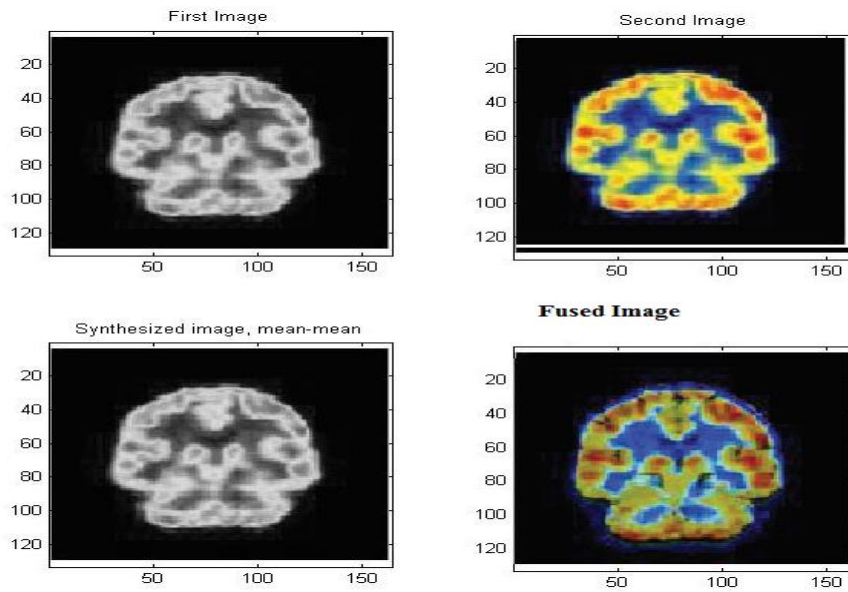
Fused image of MRI and PET normal coronal images
